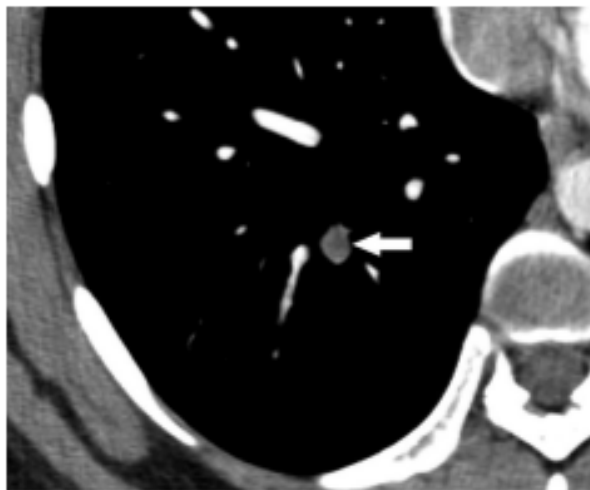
2D CT slice that shows a pulmonary embolus within the posterobasal segment of the right lower lobe artery (arrow). [5].
